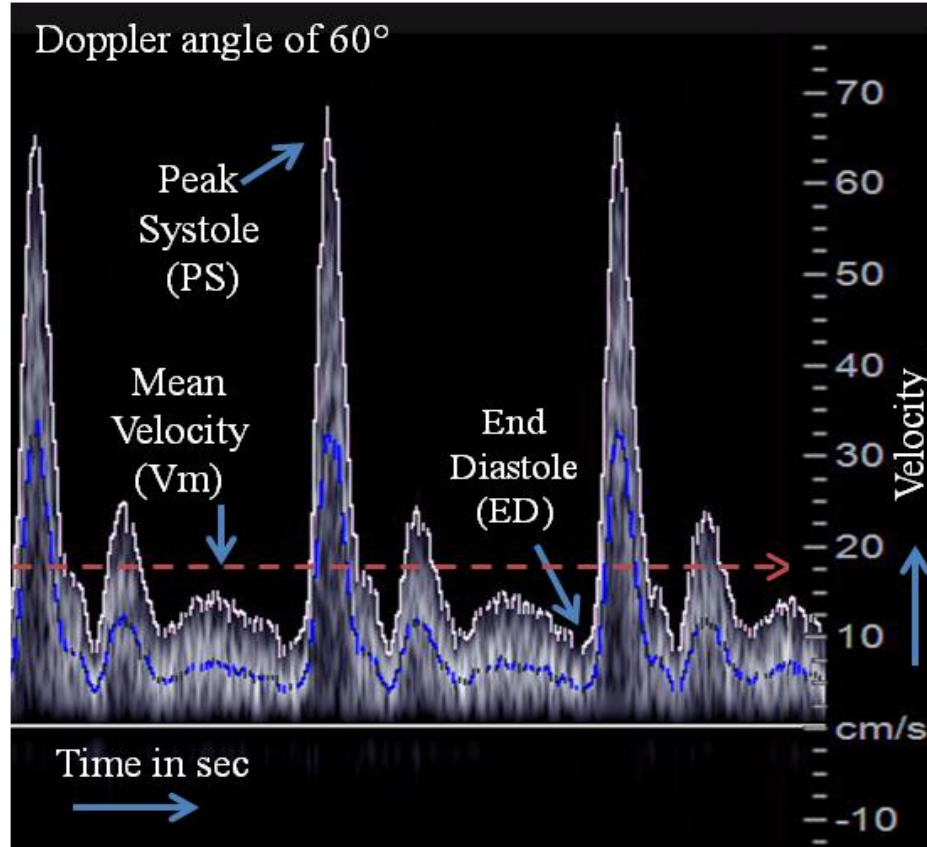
Display of Doppler Spectrum.
